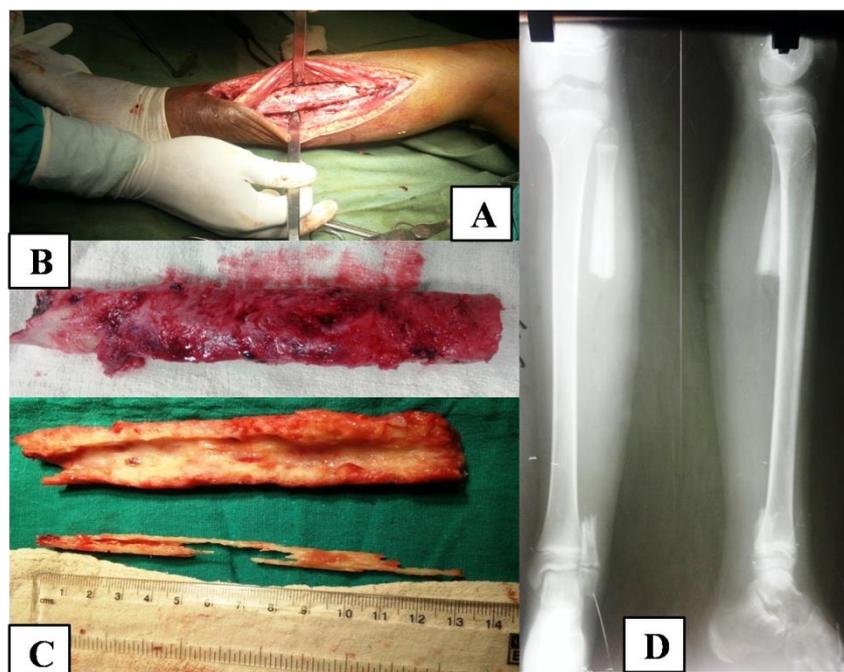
Intra operative picture showing extent of involved fibula. 3B: Excised fibula with multiple cloaca. 3C: 13cm long en blocks excised sequestrum from the medullar canal of excised fibula. 3D: Post operative radiograph of the patient.
